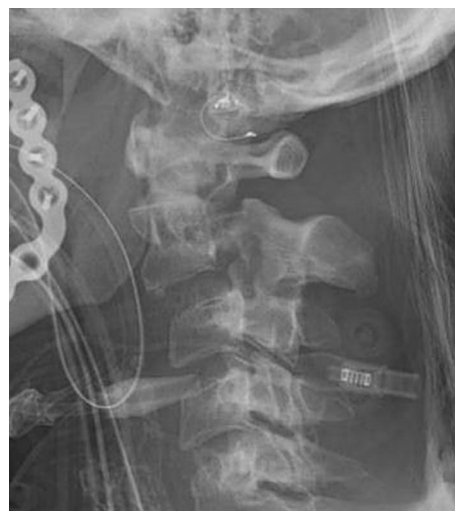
Post-reduction sagittal X-ray with 6.1 mm displacement
